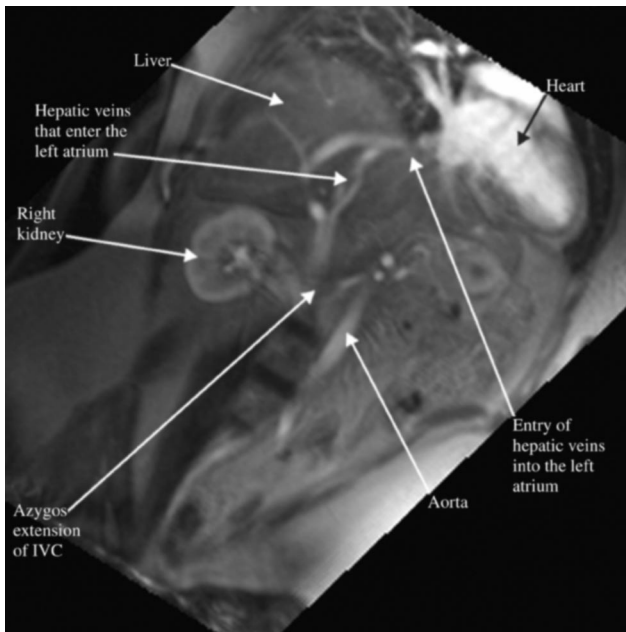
Magnetic resonance image of abdomen and chest shows the inferior vena cava, the azygos extension, and the anomalous entry of the hepatic veins into the left atrium.
